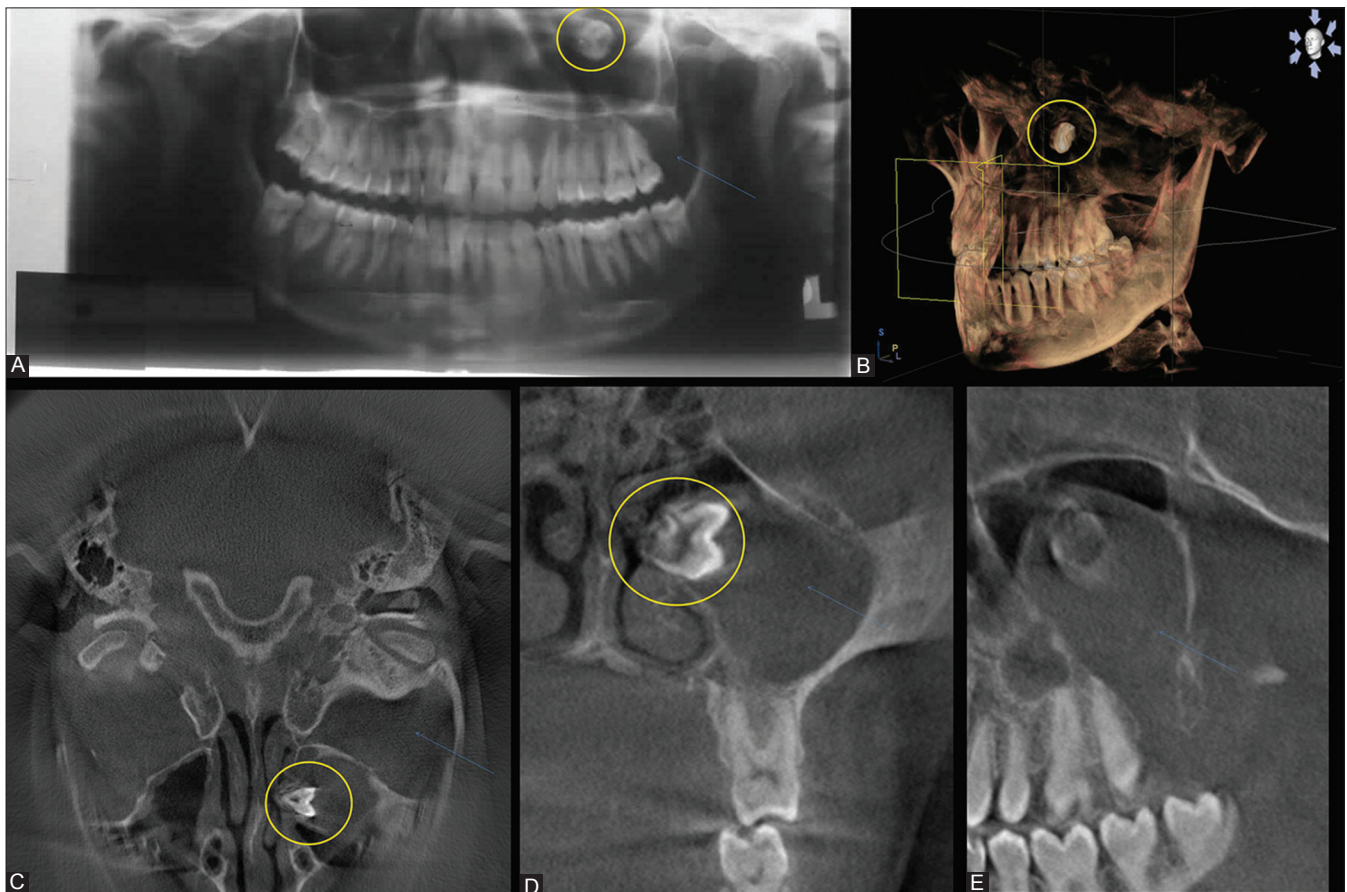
(A-E): Radiographic examination in case 2: (A) Orthopantomograph reveals 16 impacted in the region of the orbit, (B-E) Cone-beam computed tomography images with three-dimensional reconstruction (B) location of impacted tooth in the middle meatus on lateral wall of the nose (circle), and radiolucent lesion in the maxillary sinus (arrow)
